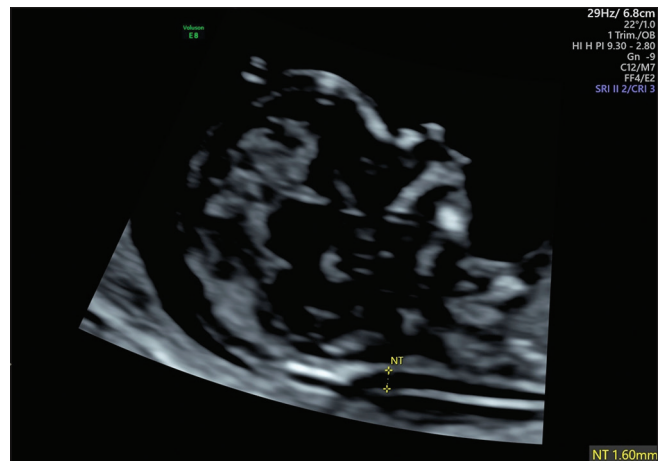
First-trimester ultrasound: midsagittal section of the fetal head raising suspicion for subtle retrognathia
